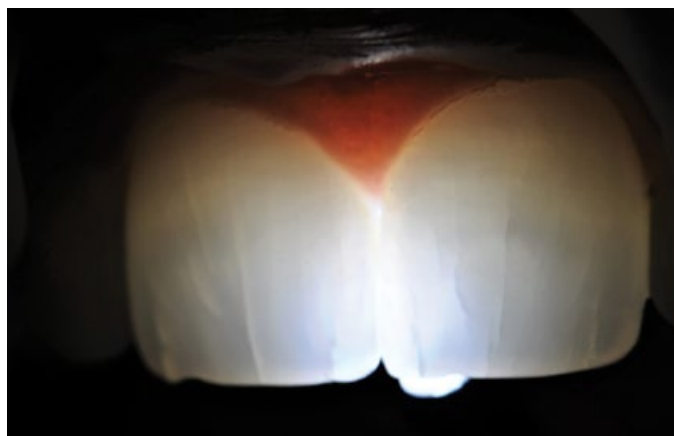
(B) Transillumination should also be used and photographically documented for the patient. Also, baseline radiographs must be taken to compare against possible future periapical abscess.
